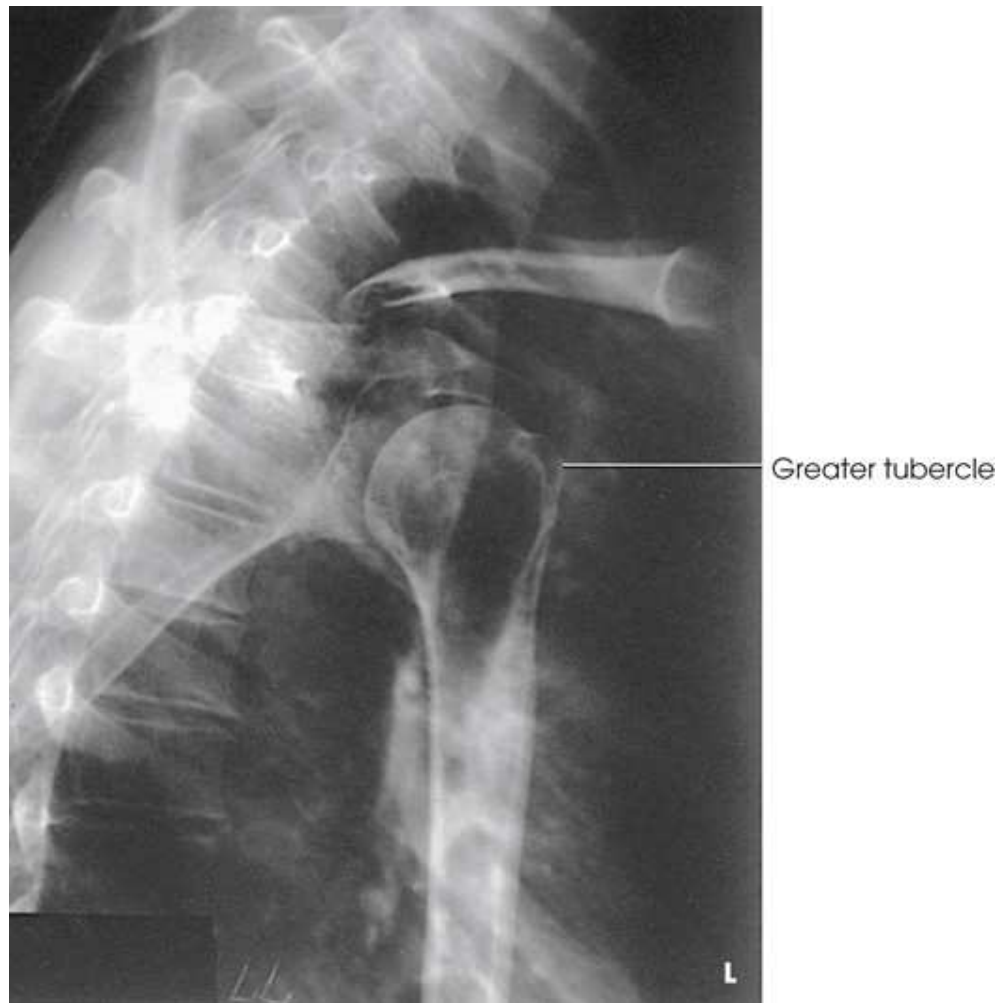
Transthoracic lateral shoulder (patient breathing): Lawrence method.
